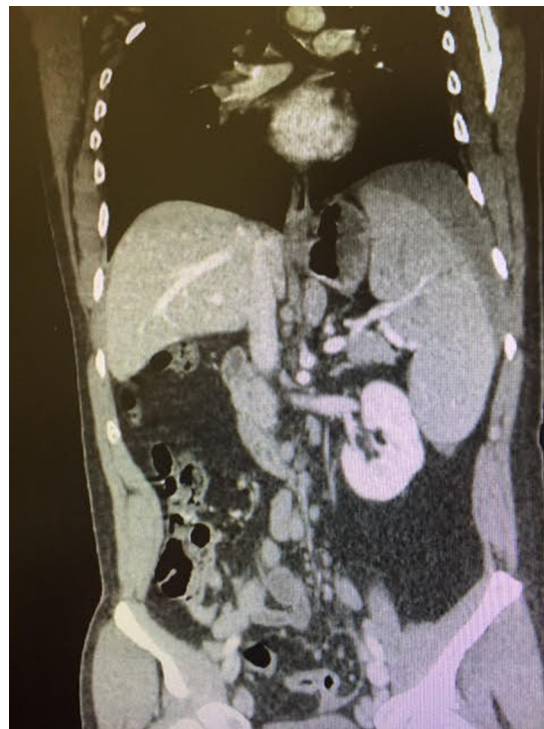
Abdominal CT coronal view with Grade V splenic laceration, hemoperitoneum, and splenomegaly.
